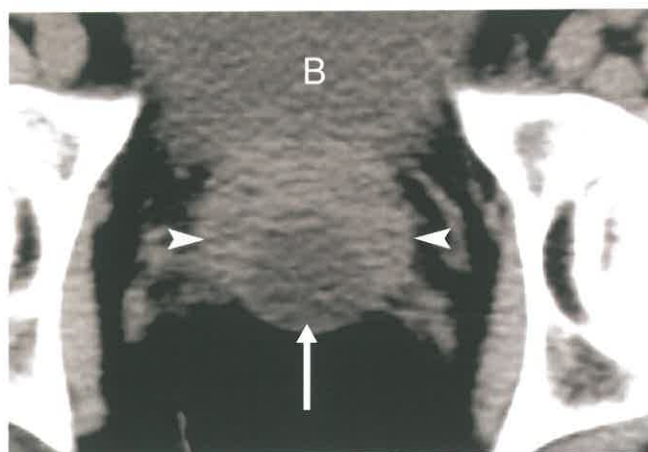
Utricle/Müllerian Duct Cyst. Axial CT without contrast shows a well-defined cyst (arrow) exactly in the midline of the prostate (between arrowheads). The patient was asymptomatic. This is an incidental finding of utricle cyst/Müllerian duct cyst. B, bladder.
